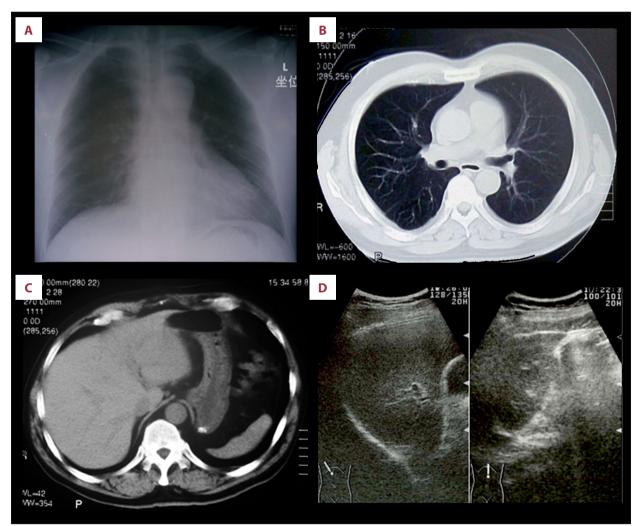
Imaging studies of the chest and abdomen. (A) Chest radiography. (B) Computed tomography (CT) image of the chest. (C) CT of the abdomen. (D) Abdominal ultrasonography image. There were no remarkable findings.
